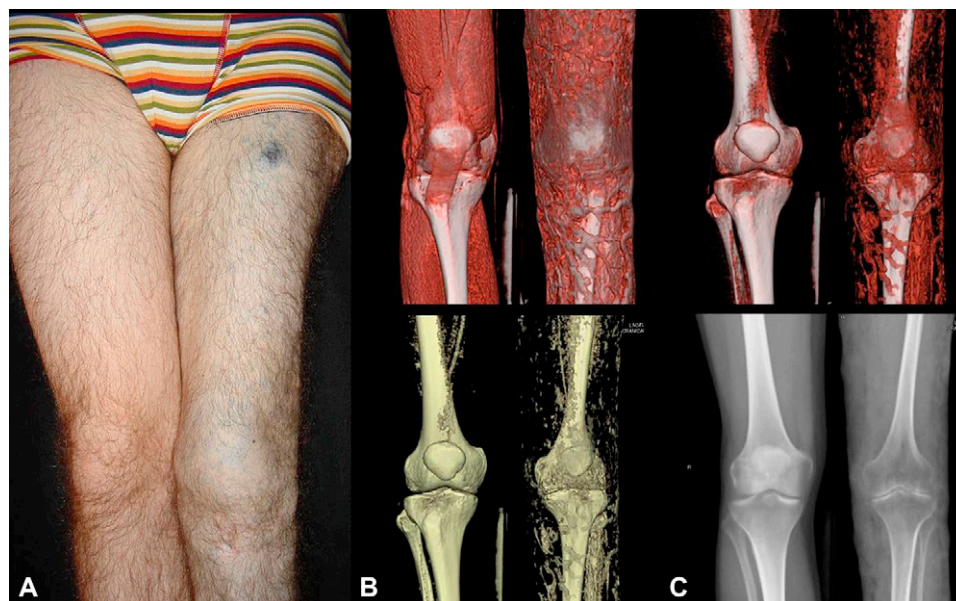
A, A 24-year-old man with extensive venous malformation of the lower limb. B and C, Indirect multidetector computed tomography venography clearly shows severe unilateral osteoporosis involving the affected extremity and significant muscular infiltration by the venous malformation. Note involvement of the knee.
